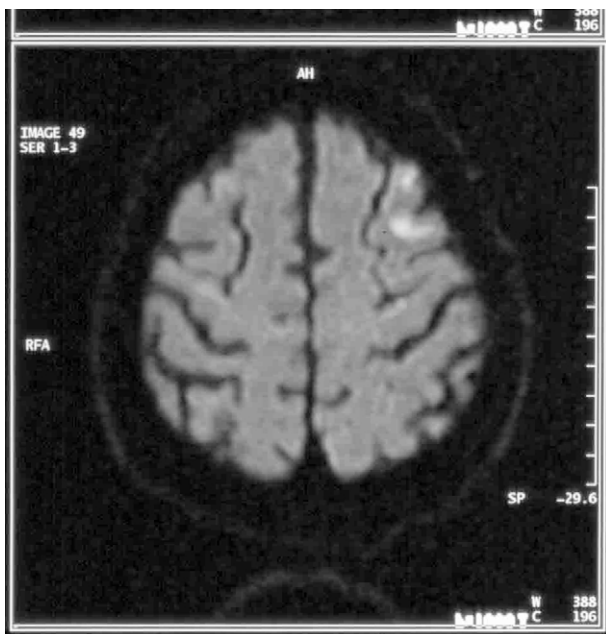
DWI performed in the same patient 24 h after surgery with a cortical DWI lesion in the left frontal middle gyrus.
